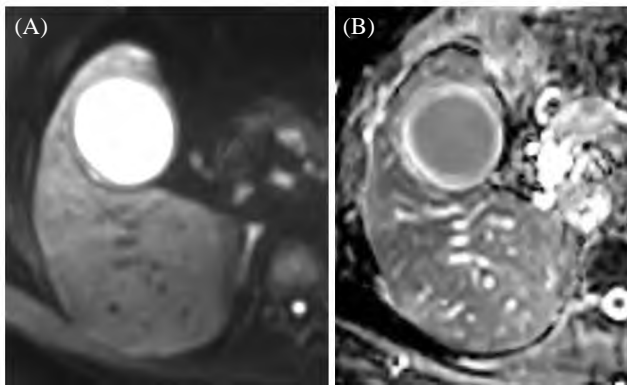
DWI (A) & ADC map (B) Images showing gall bladder abscess.
